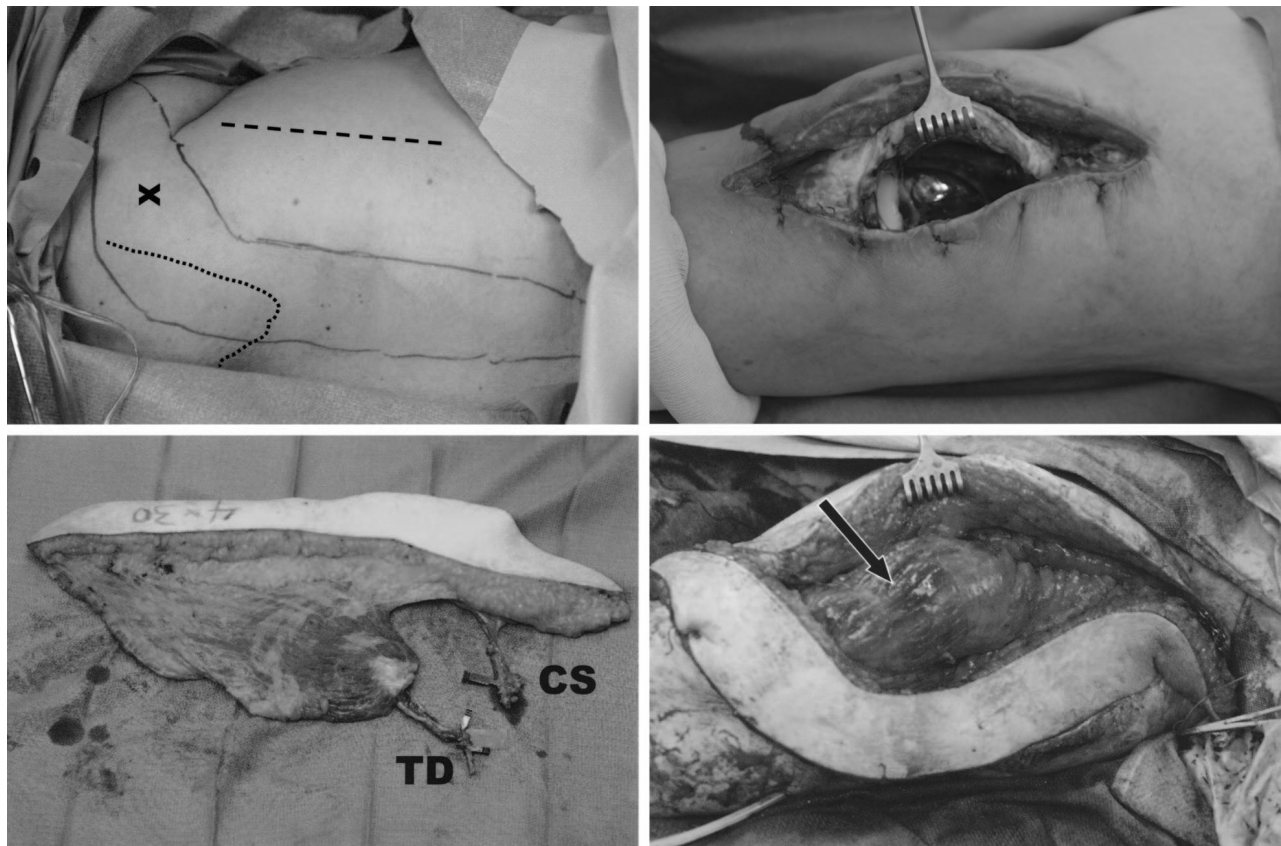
Case 1. (Above, left) Surface landmarks for planning the parascapular fasciocutaneous/latissimus dorsi muscle conjoined free flap include marking the palpable anterior border of the latissimus dorsi muscle (hashed line) and scapula (dotted line). With an audible Doppler probe, the cutaneous perforator (x) of the circumflex scapular vessels is found exiting the triangular space, contiguous to the middle third of the scapula. The boundaries of the parascapular flap (solid line) extend above that point and parallel the lateral scapular border. (Above, right) Exposed left total knee prosthesis, surrounded by indurated and inelastic skin after multiple prior joint infections. (Below, left) The combined free flap, including a long, narrow parascapular flap with a proximal extension (at right) planned to reach anteriorly around the tibia for coverage of the medial leg vascular recipient site; the attached latissimus dorsi muscle is on its undersurface. The only vascular anomaly in this series is shown here, where the circumflex scapular branch (CS) to the skin component and the thoracodorsal (TD) branch to the muscle each arose independently from the axillary vessels. (Below, right) After transfer, the muscle (arrow) as a separate layer was used to encase the joint prosthesis, and then the skin defect was closed without tension using the parascapular flap.
